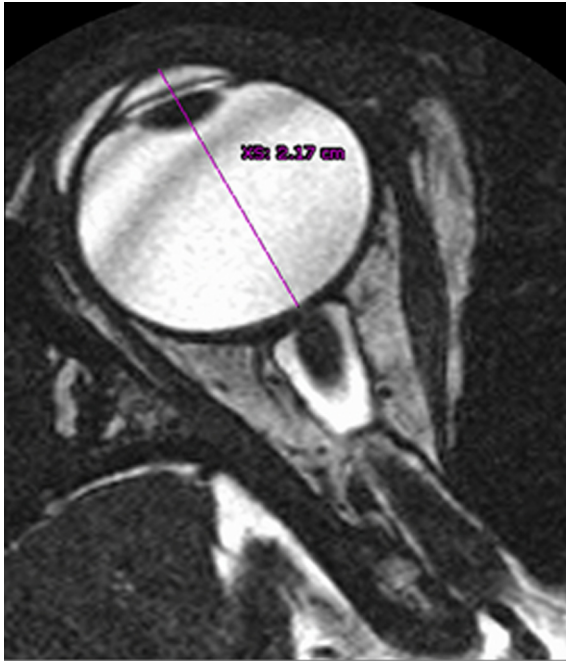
3D CISS magnetic resonance image axial plan for the right eye showing the standard plane for measurement of the axial length of globe is at the level that shows the insertions of the medial and lateral recti muscles and the optic nerve. The axial length of the globe is measured between two imaginary horizontal lines along the corneal apex anteriorly and the scleral rim posteriorly at the approximate location of the fovea.
